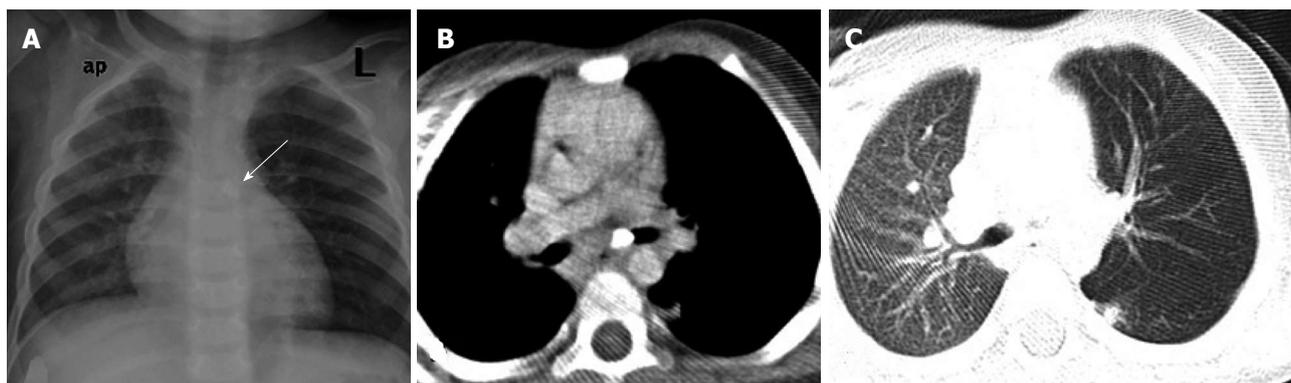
Foreign body aspiration. Chest radiograph (A) shows a radio-opaque foreign body in the left main bronchus (arrow) with hyperinflation of the left lung. Axial computed tomography images (B, C) delineate the morphology of the foreign body in the left main bronchus causing luminal compromise. There is associated air trapping in the left lung with patchy consolidation in the apical segment of the lower lobe.
